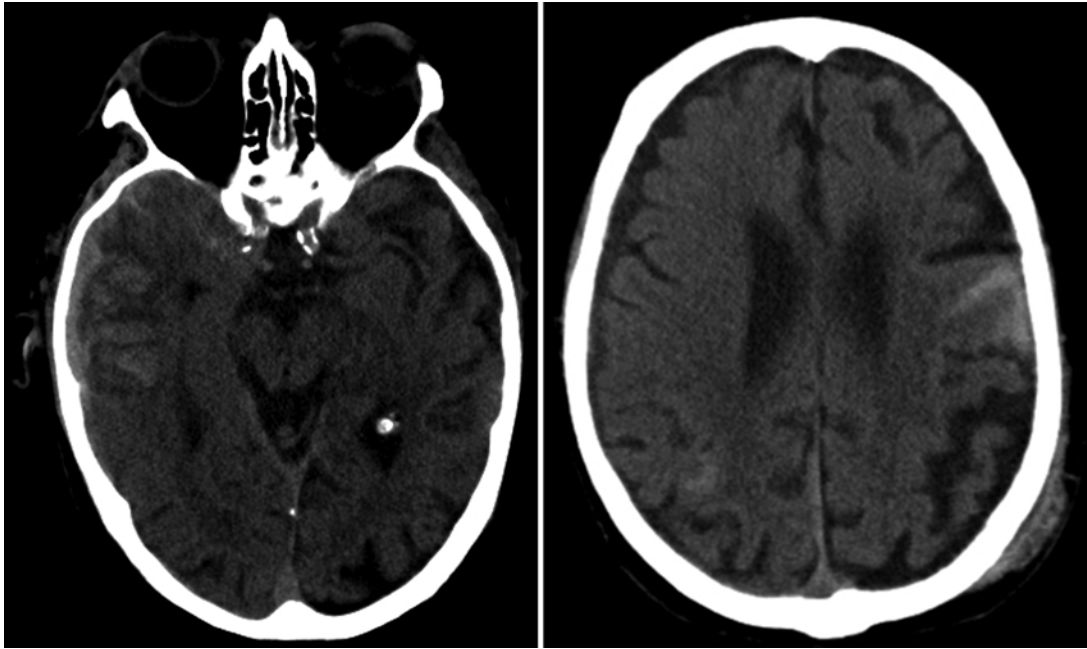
Noncontrast head CT scans obtained in the emergency department showing right temporal intraparenchymal hemorrhage with associated subdural hemorrhage and SAH (left) and left frontal subarachnoid blood (right).
